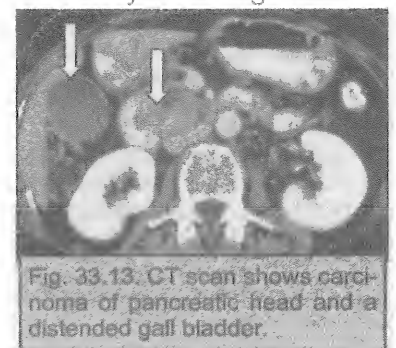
CT scan shows carcinoma of pancreatic head and a distended gall bladder.
